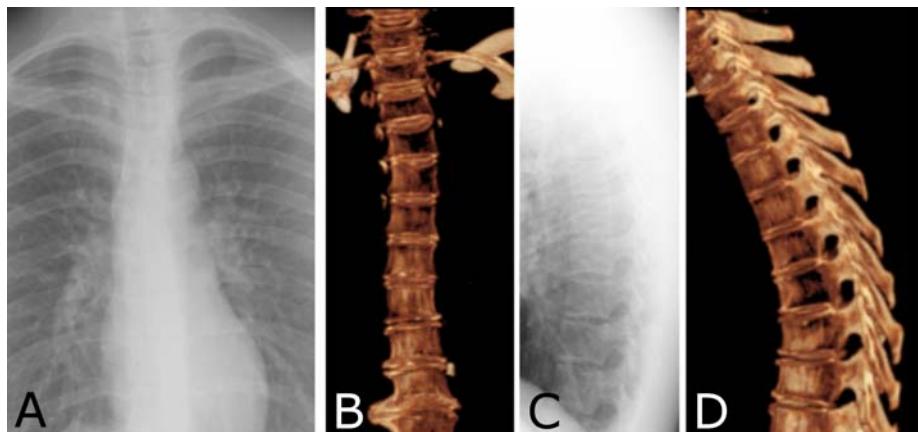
Spine. A. Frontal radiograph shows that the vertebral bodies are just visible through shadow of the heart. B. Volume rendered CT of the spine in the same orientation. C. Lateral chest radiograph shows the vertebral bodies better than the frontal view. D. Volume rendered CT image of the spine as seen on the lateral projection for comparison.
